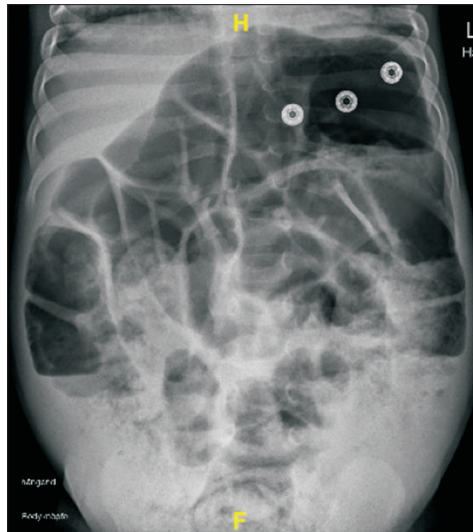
Plain abdominal radiography with contrast showing massive dilated bowel.
